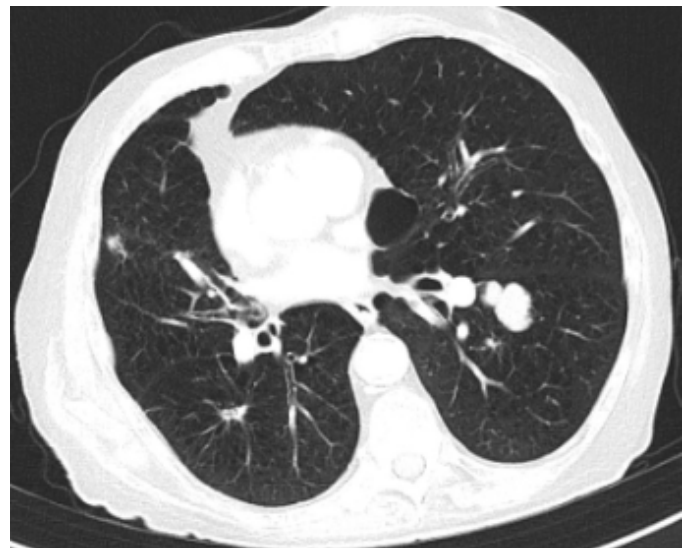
Thoracic CT 9 months after treatment initiation: reduction in the right lower lobe lesion; the left lower lobe lesion remains unchanged.
